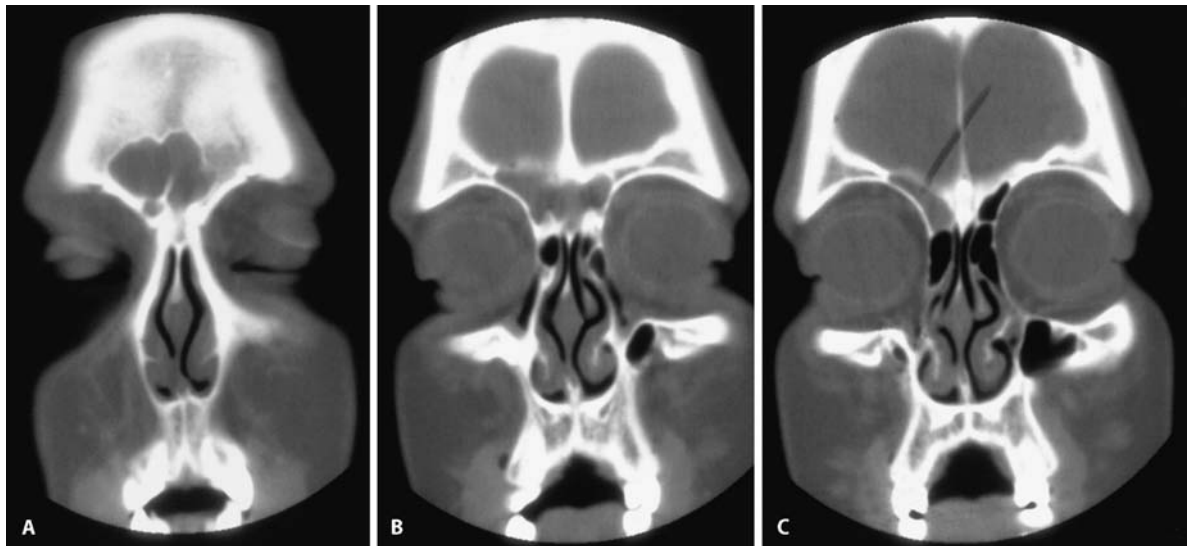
A 16-year-old girl complaining of frontal headaches for over one year was diagnosed with migraine headaches. A,B On CT scan, the frontal sinuses are completely opacified. C Prominent agger nasi cells with obstruction of the right frontal recess
